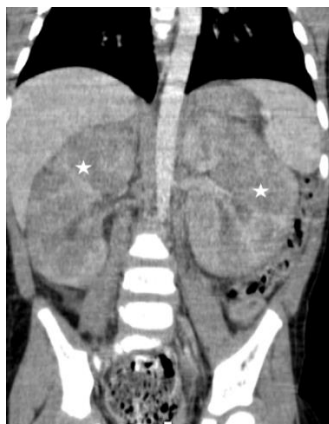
Abdomen CT scan showing bilateral nodular nephromegaly
